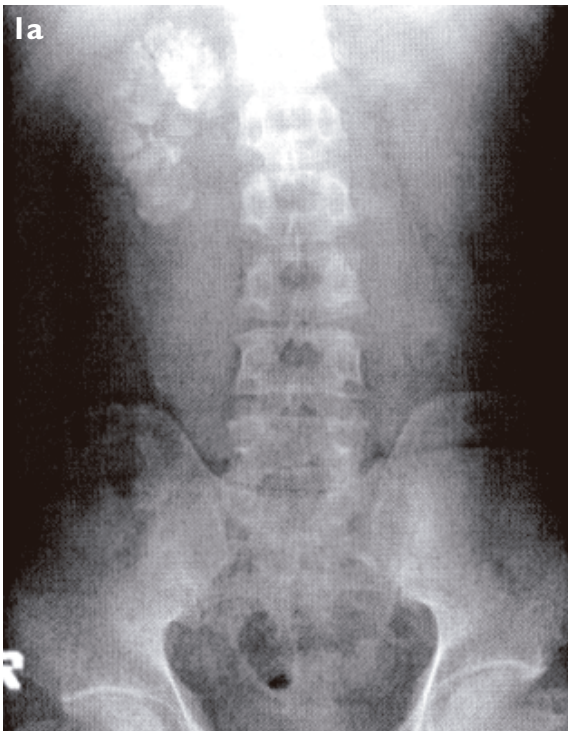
Anteroposterior abdominal radiograph.
